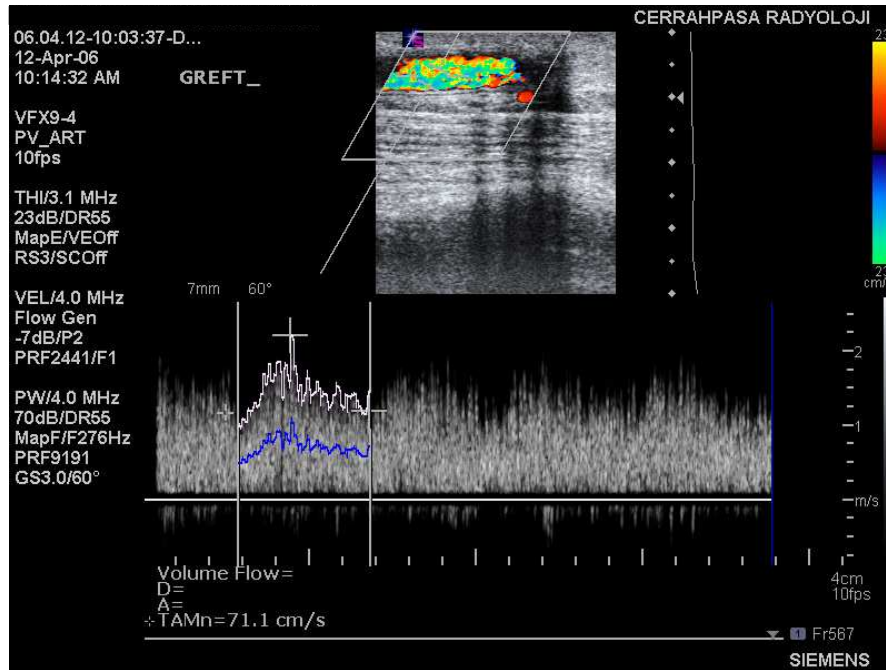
The image of AV graft to vein connection taken from the dialysis patients using color Doppler Ultrasonography
